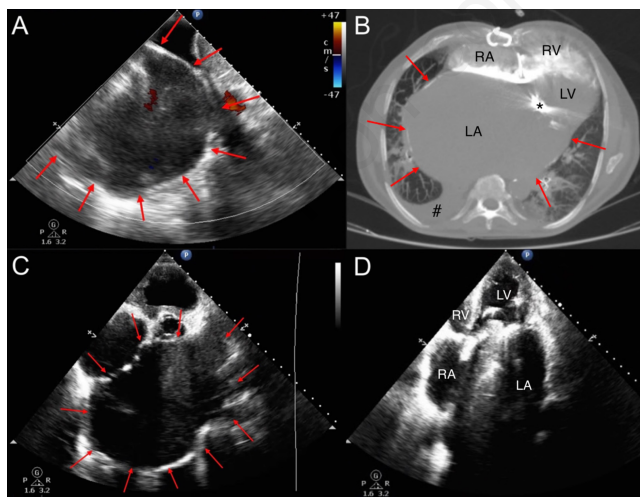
Giant left atrium. (A) lung ultrasound with color Doppler. (B) CTPA. * - prosthetic mitral valve; # - pleural effusion. (C-D) echocardiography.
